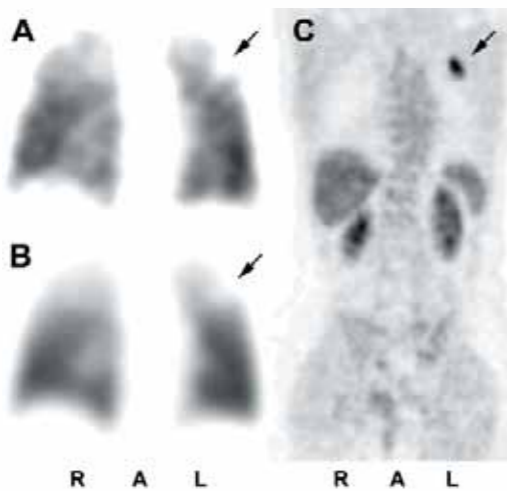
Coronal slices of a ventilation/perfusion lung scan (SPECT): both ventilation (A) and perfusion (B) show a subsegmental defect in the upper lobe of the left lung (arrows). Diagnosis: match defect, no embolism. The match defect is caused by a malignant tumour, as shown in the positron emission tomography with <sup>18</sup>F-labelled glucose (C, arrow). R = right; A = anterior; L = left.
